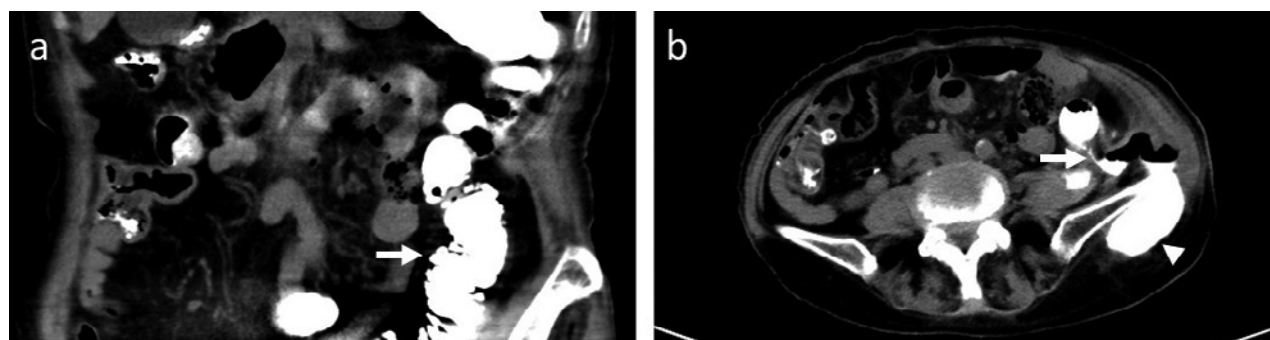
A computed tomography scan of the abdomen revealed (1) multiple small outpouchings along the descending and sigmoid colon, consistent with colonic diverticulosis (arrow in a); (2) lobulated abscesses with an air-fluid level involving the left abdominal wall (arrowhead in b), psoas muscle, and retroperitoneum adjacent to the descending colon; and (3) a contrast-opacified fistula (arrow in b) connecting the descending colon to the abdominal wall abscess.
